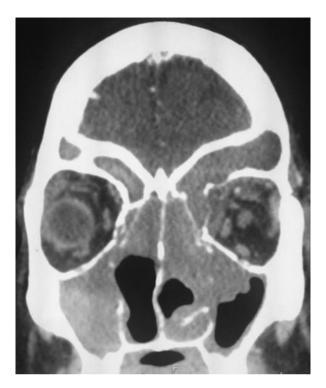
Coronal CT scan with frontal sinusitis and erosion of the orbital roof and lamina paprycea
